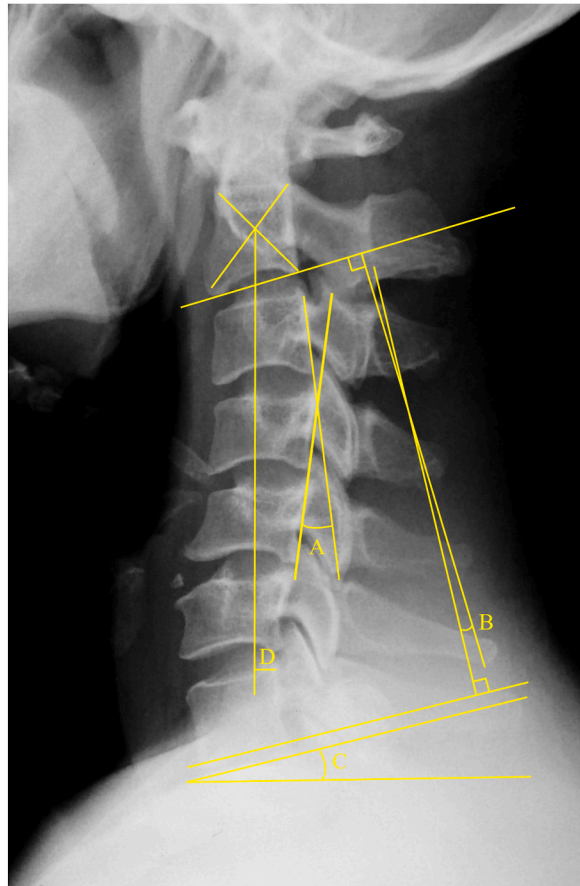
Radiographic measurements. A: Cervical LKA was measured using the Harrison posterior tangent method. B: C2-7 Cobb angle. C: T1 slope. D: C2-7 SVA. SVA indicates sagittal vertical axis.
